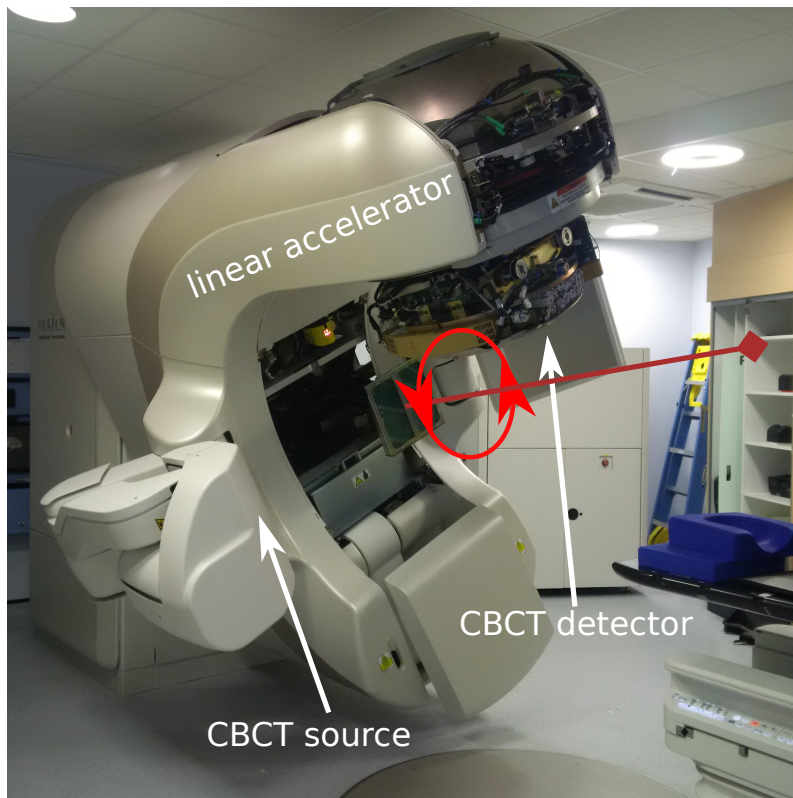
Photograph of photon therapy unit with CBCT imaging system. The line in dark red indicates the axis of gantry rotation, with an anticlockwise rotation shown with the light red arrow.
